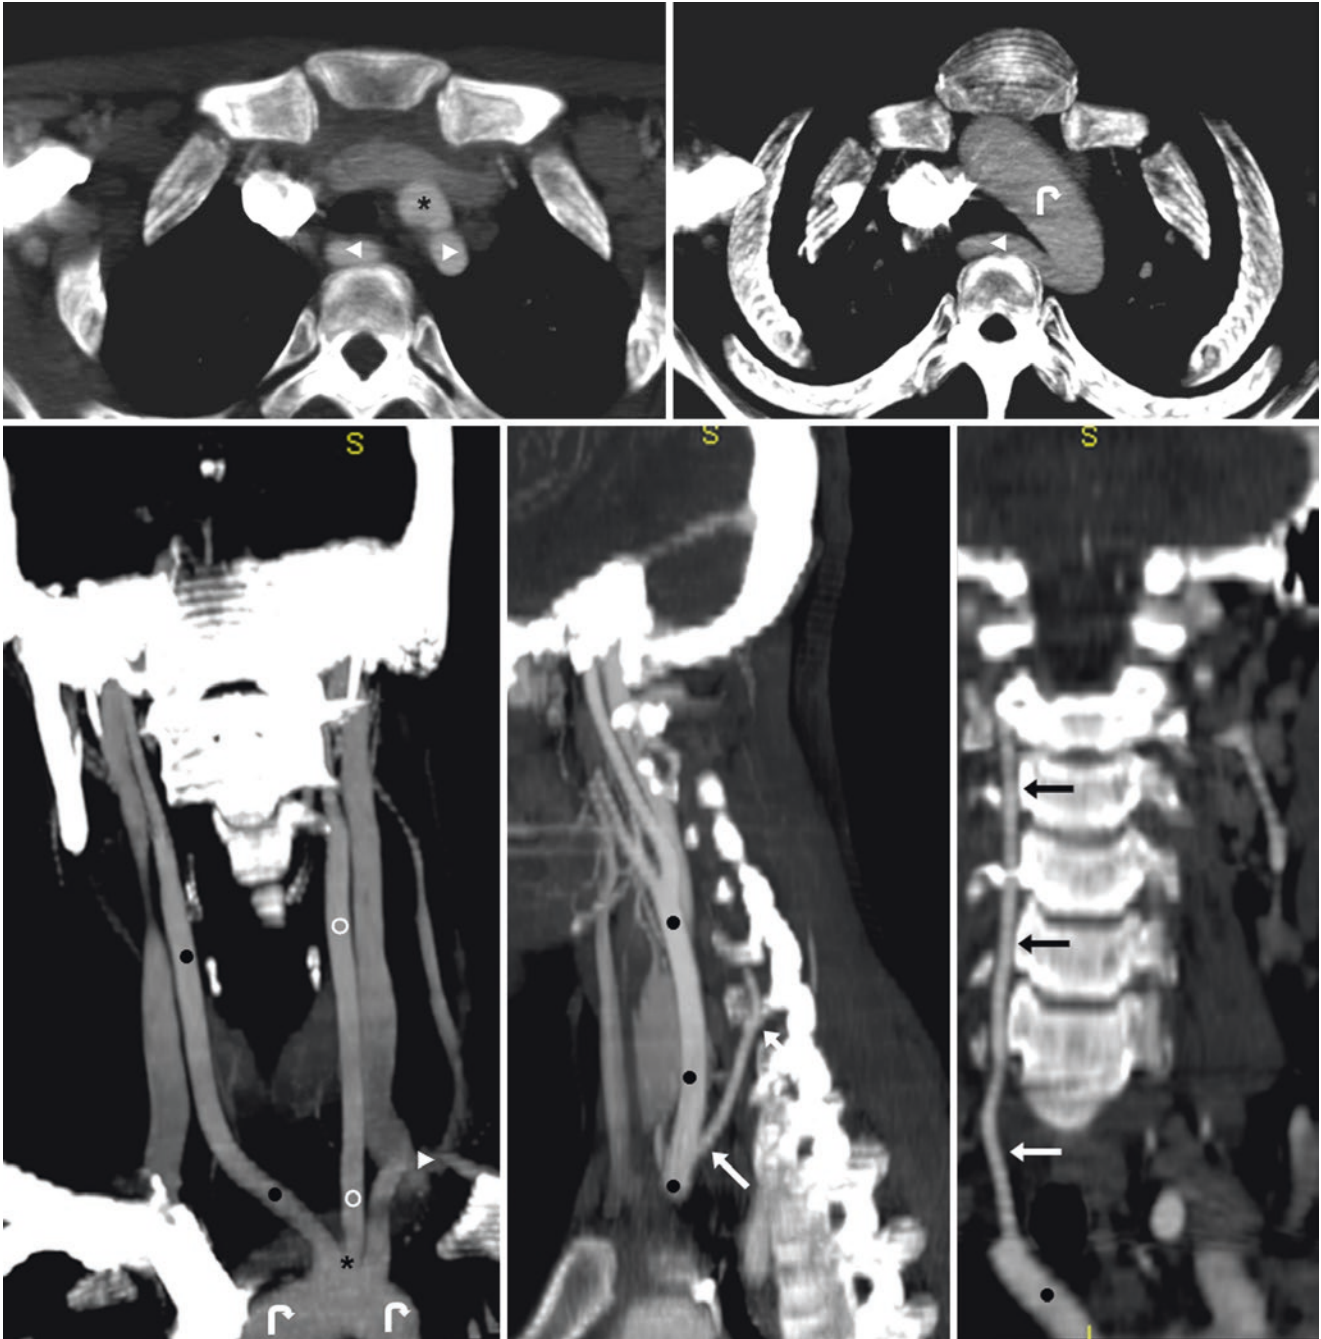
Top row: 16-year-old with a left-sided aortic arch (*curved arrow*) and a retroesophageal right subclavian artery (RSCA, *left-facing arrowhead*) on CTA axial 3-mm (*left*) and 30-mm (*right*) images. Bottom row: Note the “truncus bicaroticus” (*asterisk*) on a coronal 30-mm MPR (*left*), which is usually accompanied by an aberrant RSCA. The right vertebral artery (RVA, *arrows*) arises from the right
